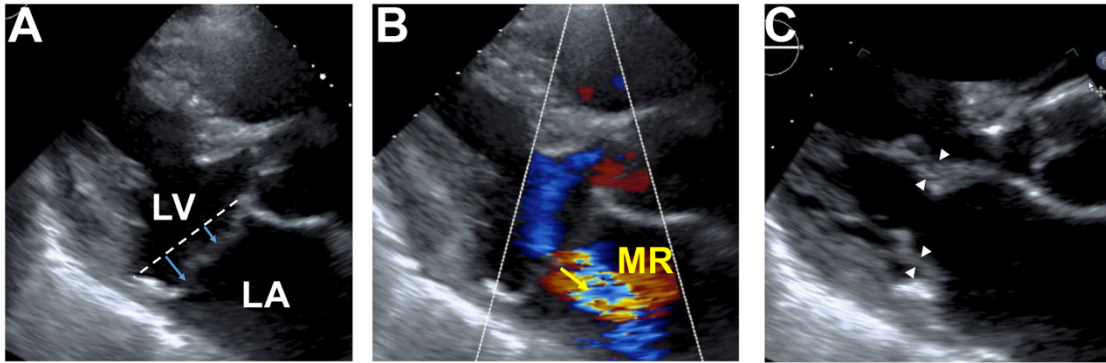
Echocardiography of Proband from Chromosome 13 family. (A) Parasternal long-axis view of proband from US family showing prolapse (blue arrows) above the annulus during ventricular systole (dotted line). (B) Significant MR is observed in this patient (yellow arrow). (C) Thickened, myxomatous appearing mitral leaflets (arrowheads).
